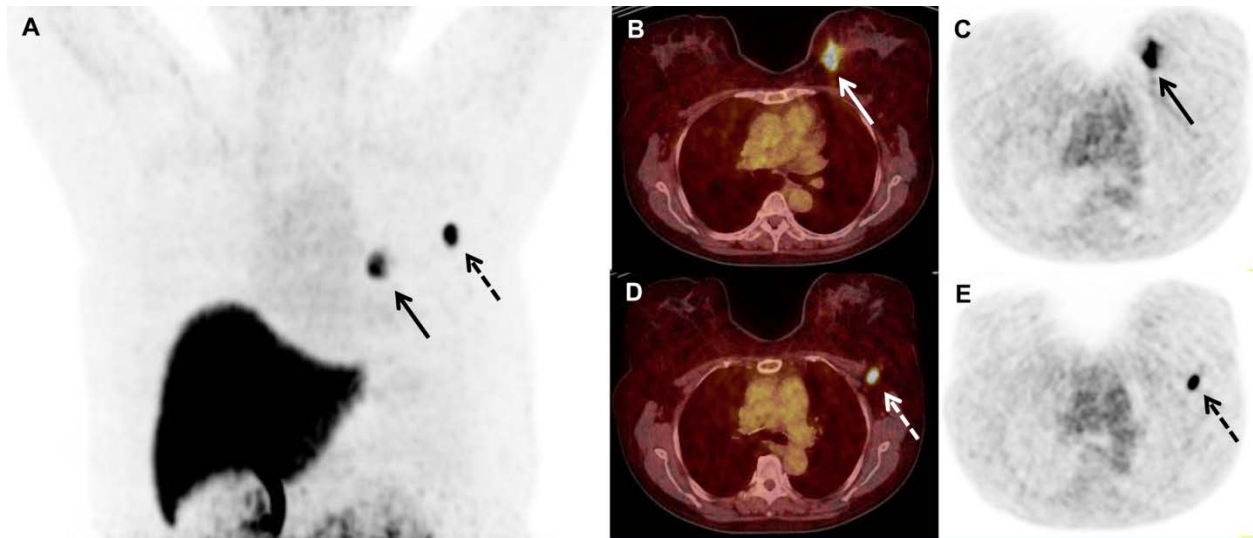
Maximum intensity projection PET (A), fused prone axial PET/CT (B and D), and prone axial PET (C and E) images demonstrate increased ^{18}F -fluoroestradiol uptake in a left primary breast cancer (solid arrow) and left axillary lymph node metastasis (dotted arrow).
